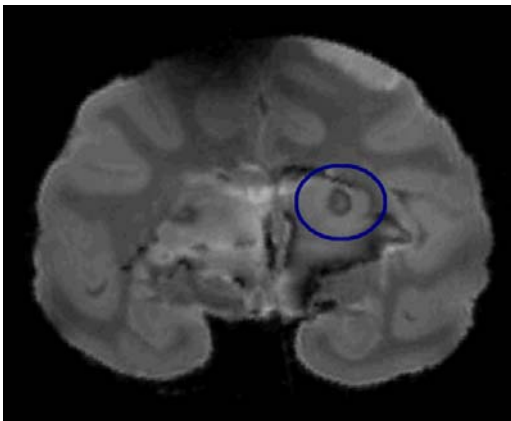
Thermal lesion induced in the brain and localised with a T2 sequence in a 7T Bruker MRI.
